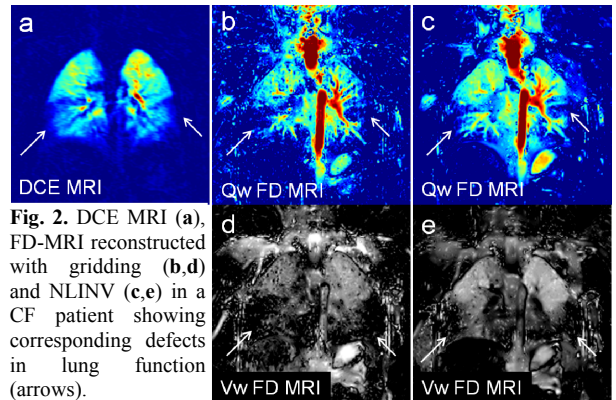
DCE MRI (a), FD-MRI reconstructed with gridding (b,d) and NLINV (c,e) in a CF patient showing corresponding defects in lung function (arrows).
